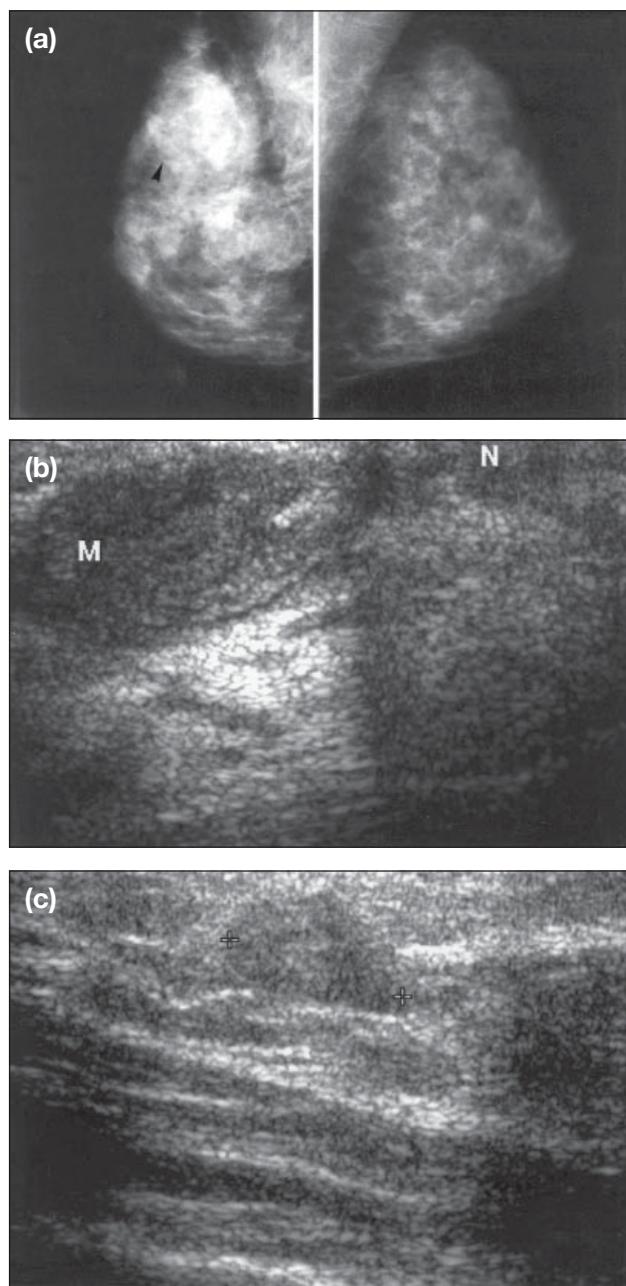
Pyogenic abscess. (a) Bilateral medio-lateral oblique mammogram of a 30-year-old postpartum woman shows focal asymmetrical density and mild architectural distortion at the superior aspect of the right breast (small black arrowhead). (b) Ultrasound study of the right breast shows multiple oval hypoechoic masses with posterior enhancement. M represents the largest abscess at the subareolar region, which extends to the nipple (N). (c) A smaller abscess is shown.
